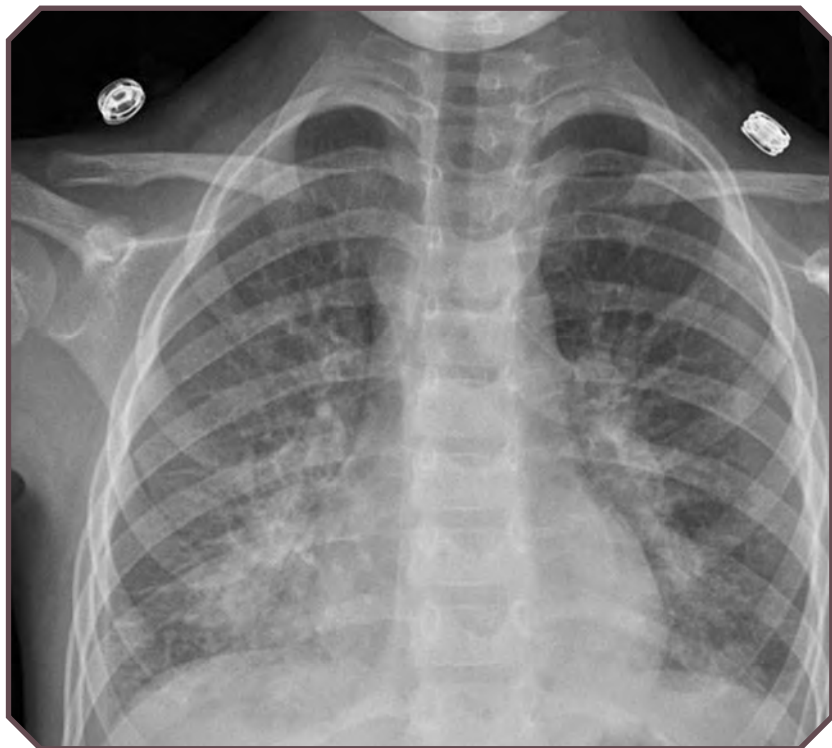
Streptococcus pneumoniae* in a 7-year-old child with high fever, increased white blood cell count, and a positive blood culture finding. Frontal chest radiograph shows bilateral disease with perihilar markings and lobar opacity in the right middle lobe. Note: This child had not been immunized.
